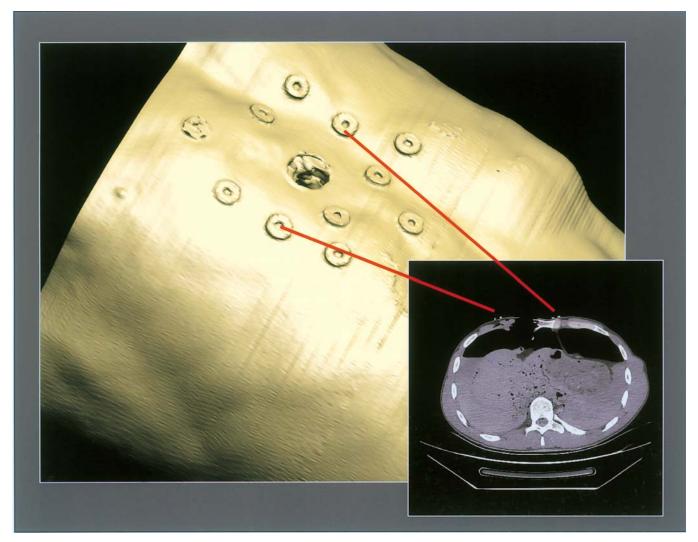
Radiological landmarks (Multi-Modality Markers) are used to give the local orientation between the cross-section and 3D reconstruction of the CT.
